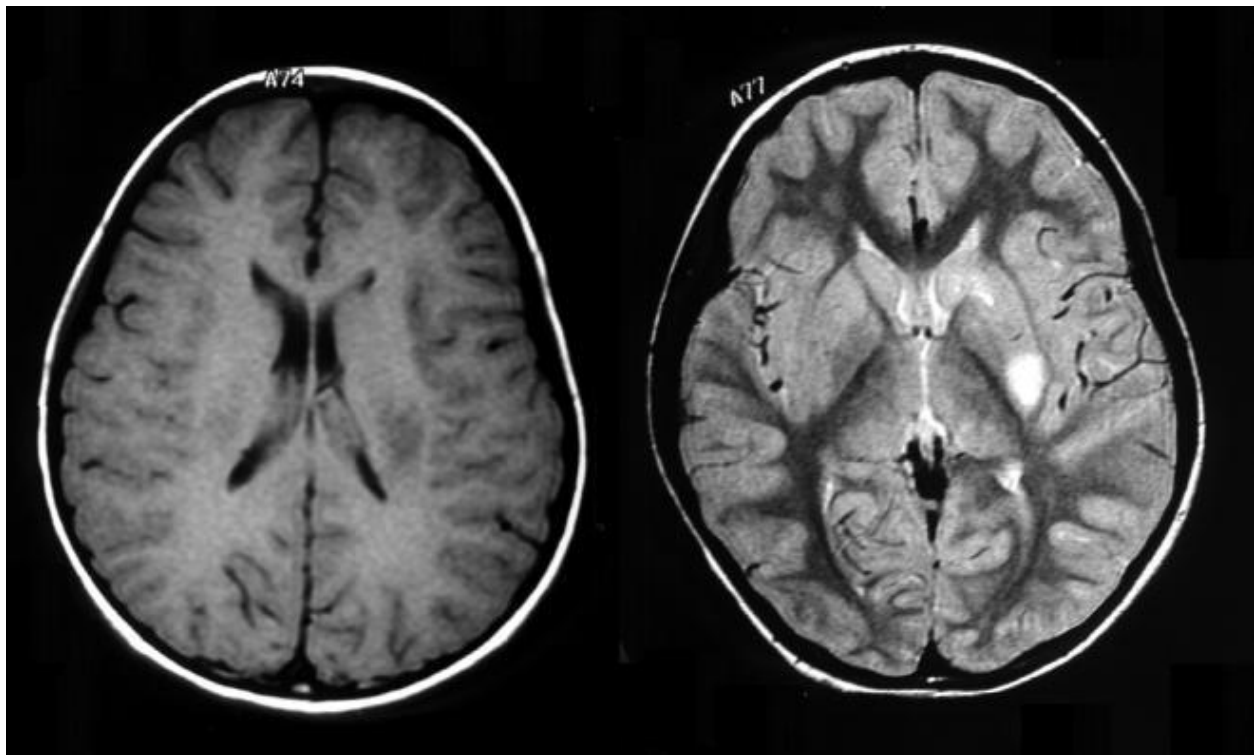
Comparison of T1 and T2 weighted images. T1 image (left) compared to T2 image (right). Each of the three tissues main tissues in the brain have distinct contrast values, making MRI imaging excellent for brain imaging. Image from <http://www.hawaii.edu/pediatrics>. Used under Fair Use.
